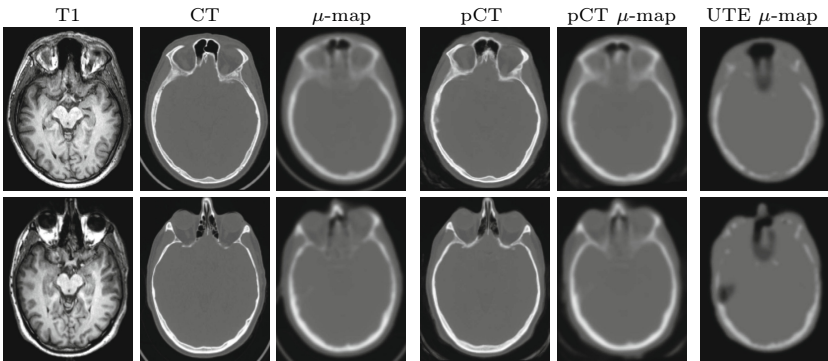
Acquired T1-weighted MRI, CT and μ -map, pseudo CT and μ -map generated by the proposed method and UTE-based μ -map for two subjects
